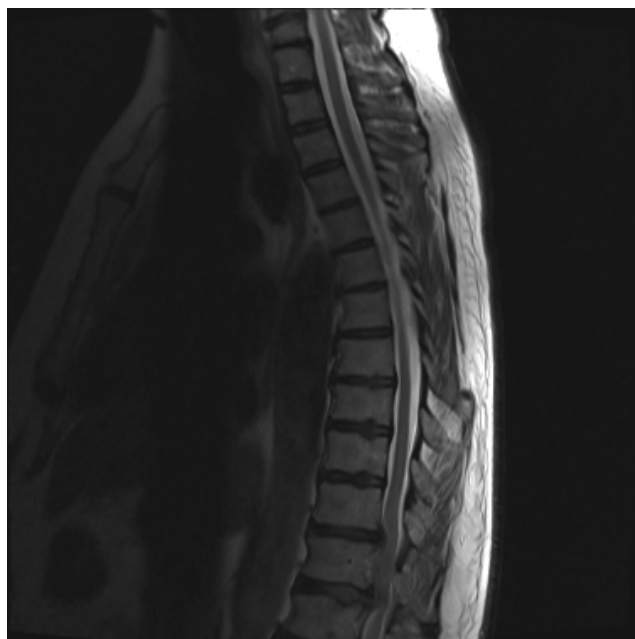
MRI T2 Sagittal view showing the compression at the lower thoracic levels.
